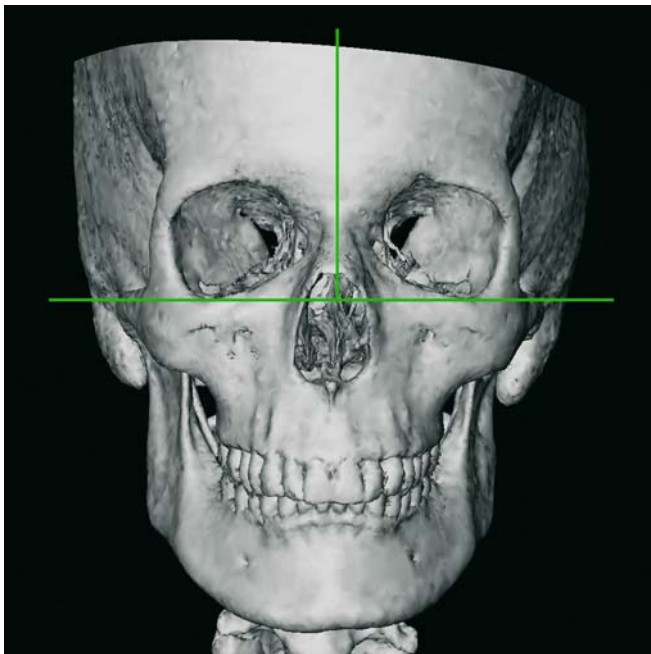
Virtual positioning of the skull in the frontal view of the 3-D hard tissue surface representation (3-D CT, patient K.C.)
